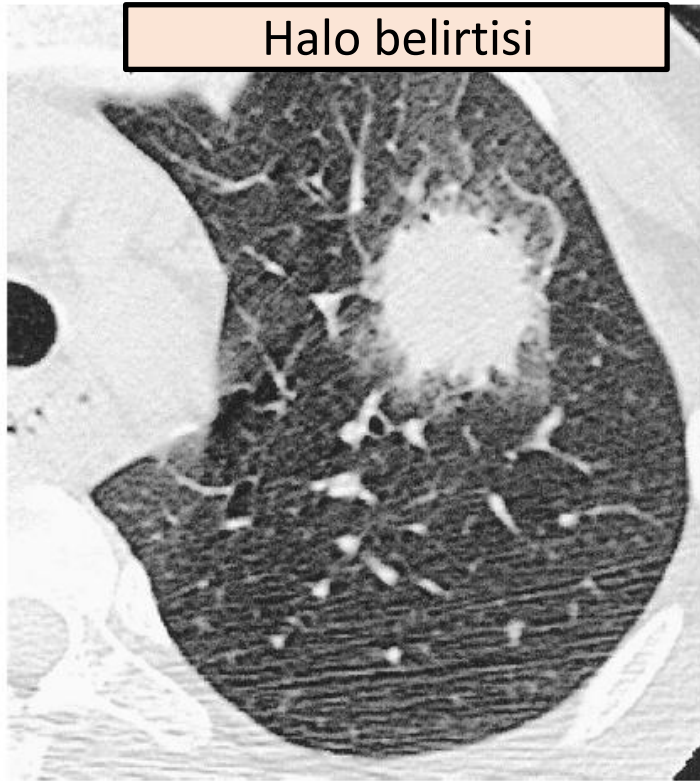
CT halo sign. This first thoracic CT scan (day 0) was performed in a patient with febrile neutropenic leukemia. The ground glass attenuation surrounding the nodule was considered a typical halo sign. The diagnosis of IPA was considered highly likely, and antifungal treatment was started.
